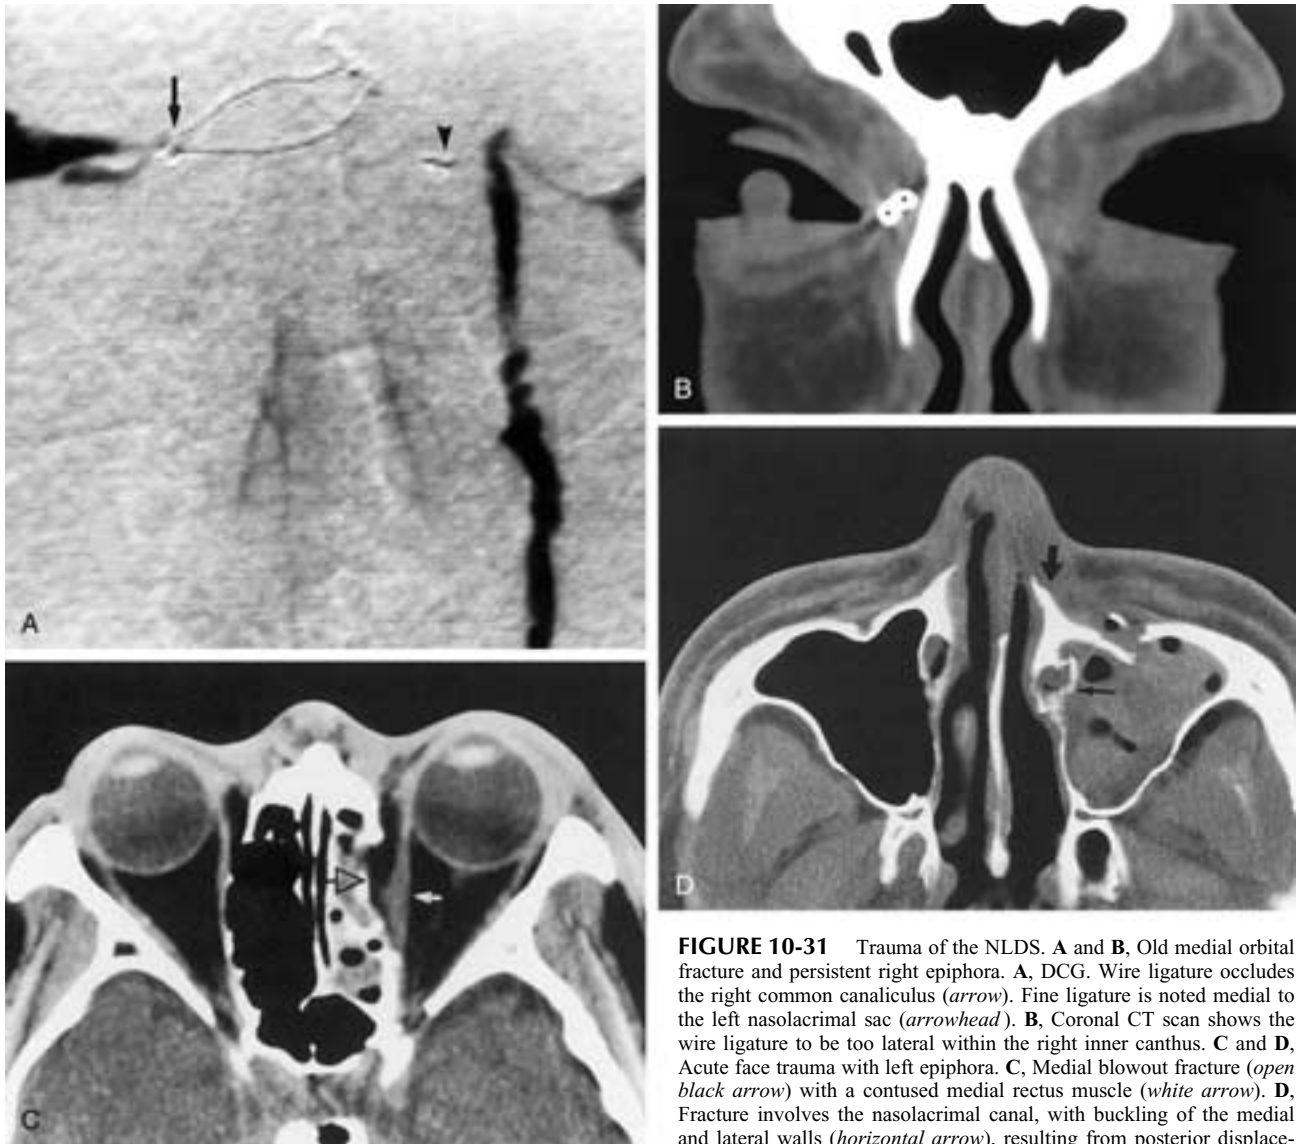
Trauma of the NLDS. A and B, Old medial orbital fracture and persistent right epiphora. A, DCG. Wire ligature occludes the right common canaliculus (*arrow*). Fine ligature is noted medial to the left nasolacrimal sac (*arrowhead*). B, Coronal CT scan shows the wire ligature to be too lateral within the right inner canthus. C and D, Acute face trauma with left epiphora. C, Medial blowout fracture (*open black arrow*) with a contused medial rectus muscle (*white arrow*). D, Fracture involves the nasolacrimal canal, with buckling of the medial and lateral walls (*horizontal arrow*), resulting from posterior displacement of an anteromedial maxillary fragment (*vertical arrow*). (C and D Courtesy of Dr. Lyne Noël de Tilly, Toronto, Canada.)
